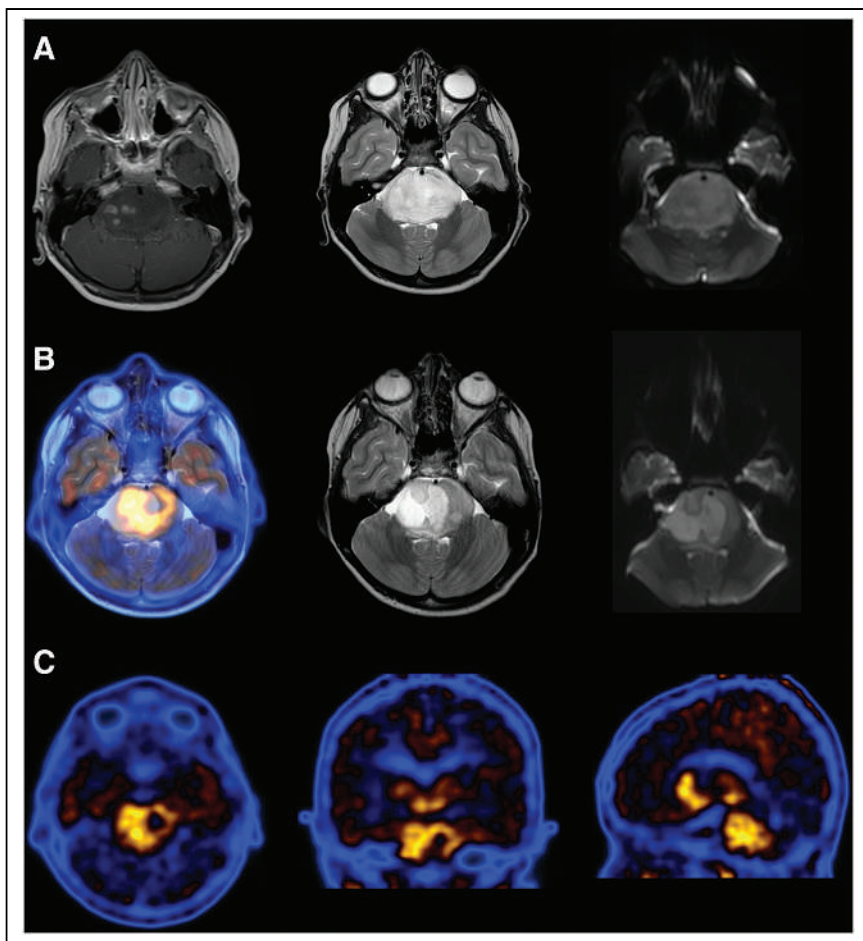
No clear change in size of initial diffuse intrinsic pontine glioma tumor 9 mo after initial MRI. Changes in appearance on different sequences showed T2-weighted and diffusion-weighted MRI signal distribution changes. ^{18}F -DOPA scan fused with follow-up MRI clearly delineates tumor viability and recurrence. (A) From left to right: initial axial T1-weighted contrast-enhanced, initial axial T2-weighted, and initial axial diffusion-weighted MR images. (B) From left to right: axial ^{18}F -DOPA T2-weighted 9-mo follow-up PET/MR, axial T2-weighted 9-mo follow-up MR, and axial diffusion-weighted 9-mo follow-up MR images. (C) From left to right: axial ^{18}F -DOPA, coronal ^{18}F -DOPA, and sagittal ^{18}F -DOPA PET images.
